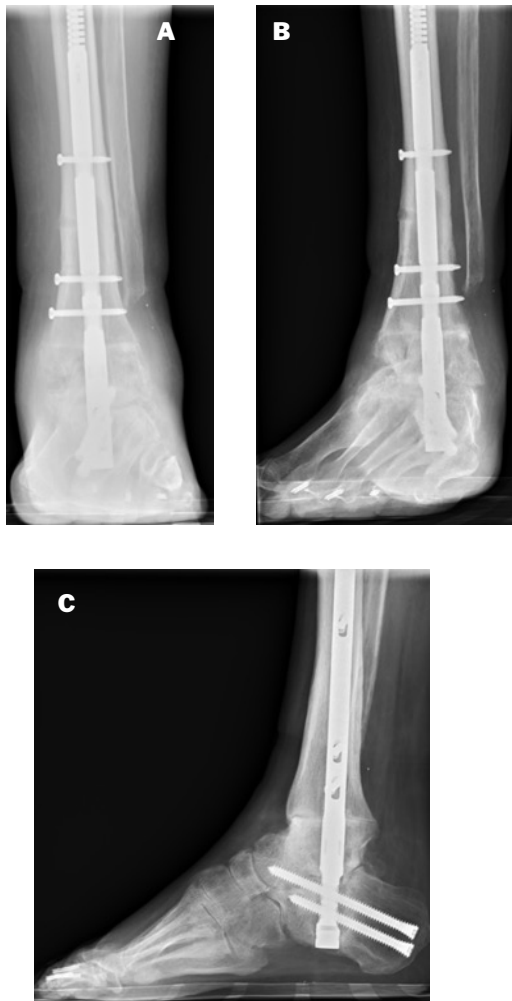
(A-C): Three WB ankle radiographs 3 months post op showing signs of fusion across the ankle and subtalar joints and union of the tibial osteotomy. A. AP view B. Mortise view C. Lateral view
